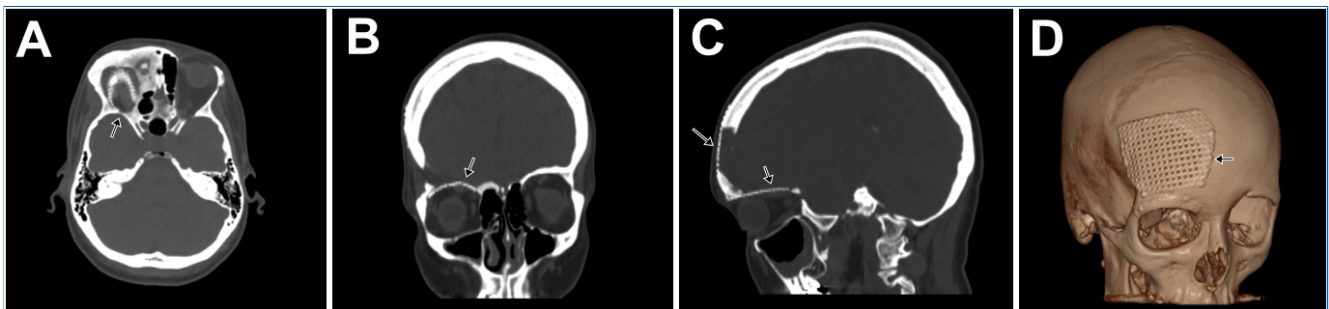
Two-year follow-up CT scan images with no contrast medium injection. (A) Axial cut showing the titanium plate well-adapted in the right orbital roof and the right frontal bone area; (B) Coronal cut showing the titanium plate well-adapted in the right orbital roof and right frontal bone area; (C) Sagittal cut showing the adaptation of the titanium plate in the right orbital roof; (D) 3D reconstruction of both well-adapted titanium plates.
